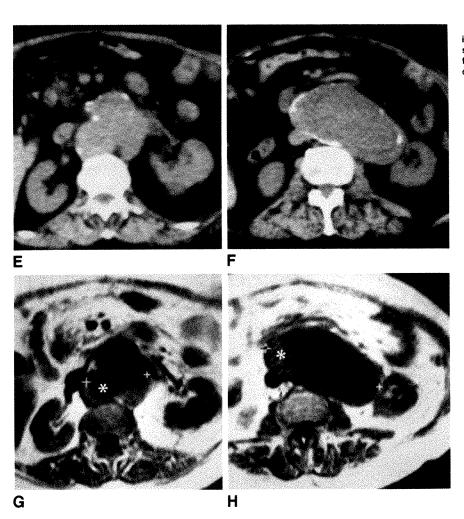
E-H, Axial CT scans (E and F) and MR images, 630/30 (G and H), at approximately the same levels. MR better differentiates patent lumen from thrombus (asterisks) in patient to whom IV contrast material could not be given.
